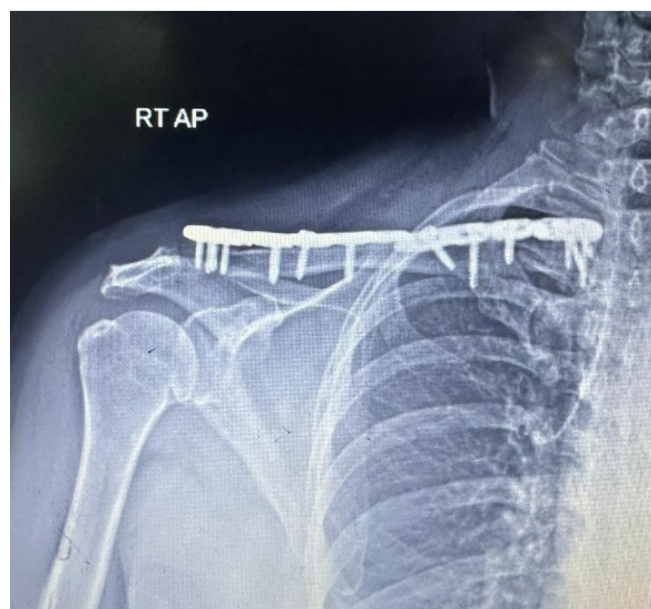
Post-operative X-ray, showing reduced bipolar clavicle fracture.
